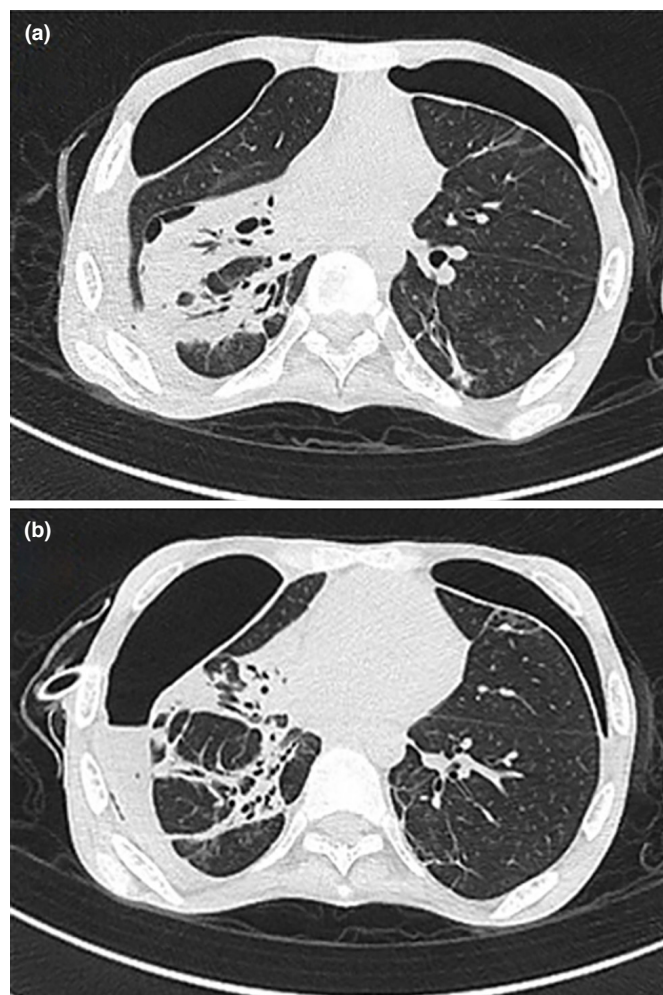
Chest computed tomography (CT) initially and three months after the pulmonary rehabilitation (PR) program: (a) Initial chest CT; (b) Chest CT at three months after the PR program
